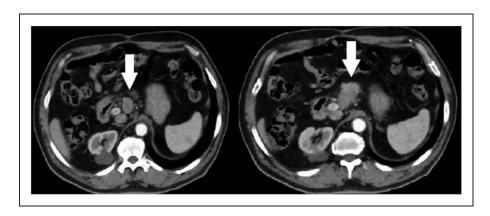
Abdominal computed tomography images of a 71-year-old man showing a solid mass involving the body of the pancreas (arrow).
